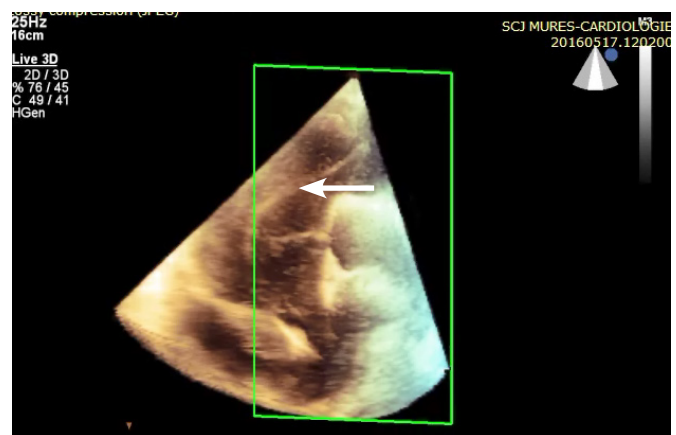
3D transthoracic echocardiography (live 3D) – suprasternal long axis view of the aortic arch: visualisation of the dissection membrane (arrow)
